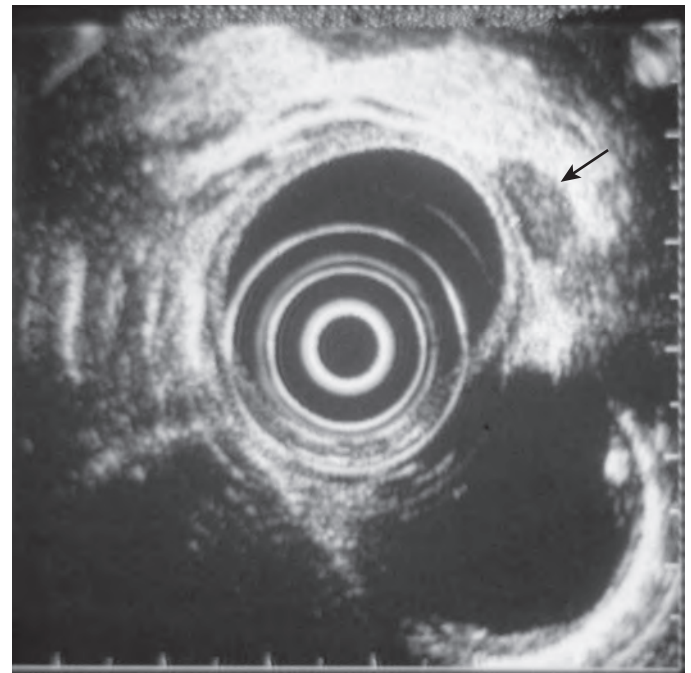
Endoscopic ultrasound of lymph node metastasis from esophageal carcinoma. The enlarged node is manifested by a hypoechoic focus (arrow).
